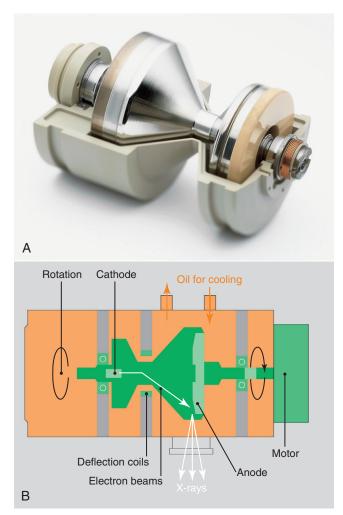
A, This very high capacity x-ray tube revolves in a bath of oil for complete heat dissipation. B, The cooling capacity is greater than any heat load. (Courtesy Siemens Medical Systems.)
